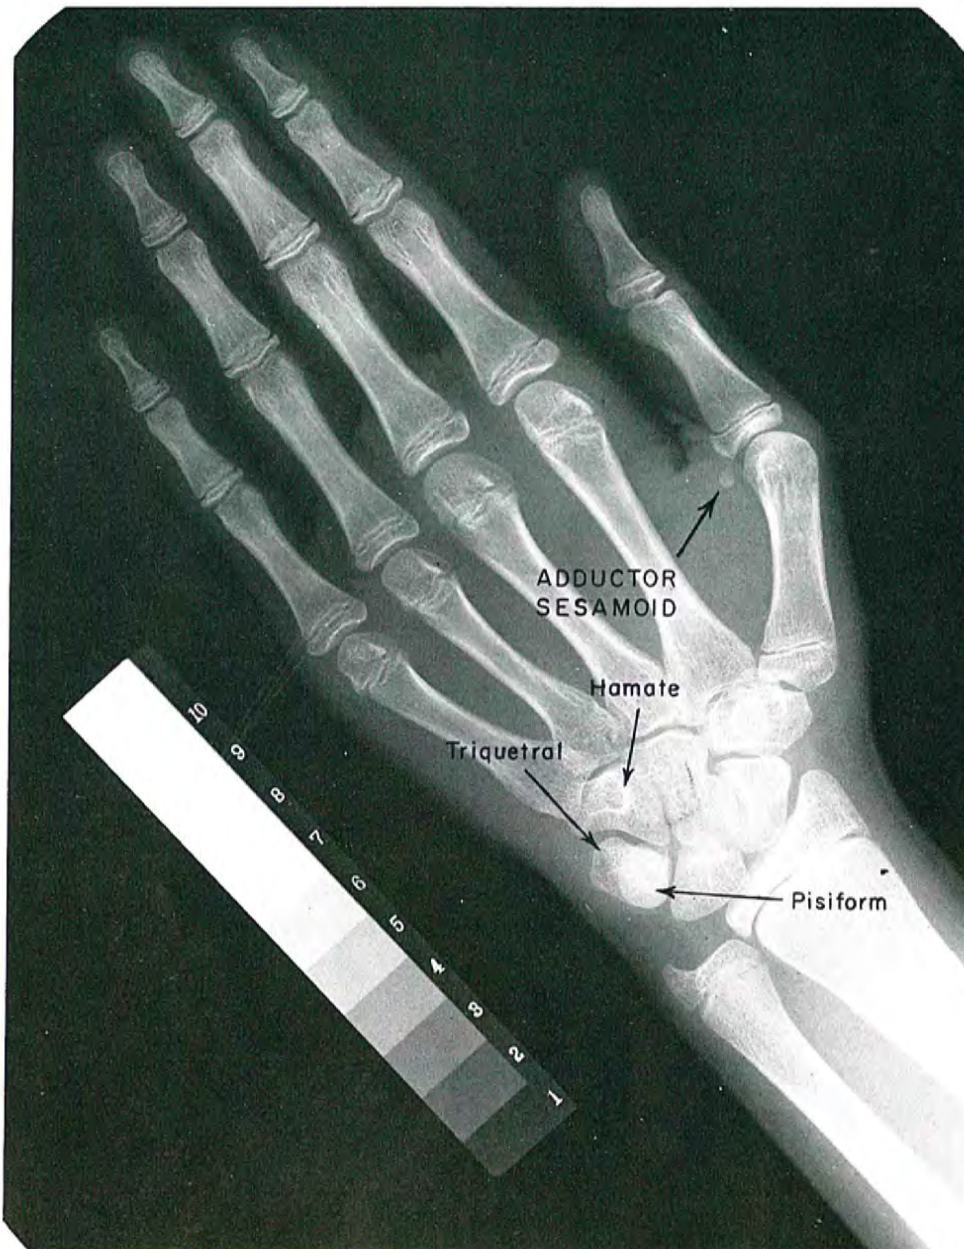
Hand-wrist radiograph with the adductor sesamoid indicated as well as the relationship of the pisiform, triquetral, and hamate. The Webber³⁴ step wedge densitometer is shown adjacent to the hand.
